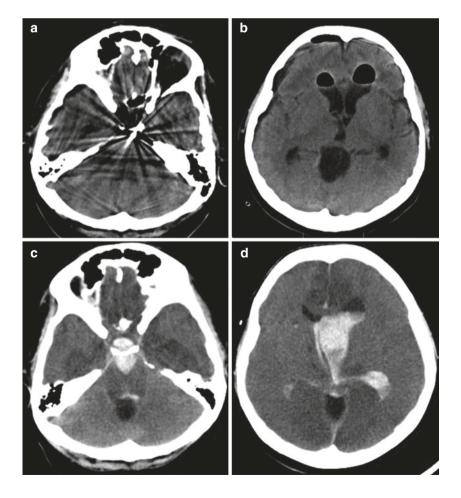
Neuroimaging findings during the postoperative course. Two weeks after the primary intervention, computed tomography (CT) showed complete resolution of the intraventricular hematoma (a, b). At the time of clinical deterioration, which resulted from pseudoaneurysm rupture 4 weeks after the primary intervention, CT demonstrated diffuse prepontine and intraventricular hemorrhage with acute hydrocephalus (c, d)
